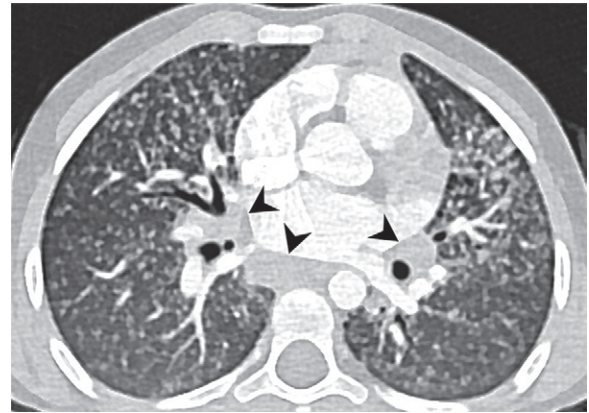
Miliary tuberculosis in a 3-year-old boy. Axial CT image (lung window) shows numerous small uniform nodules in both lungs without zonal predominance. Note the mediastinal and hilar lymphadenopathies (arrowheads).
